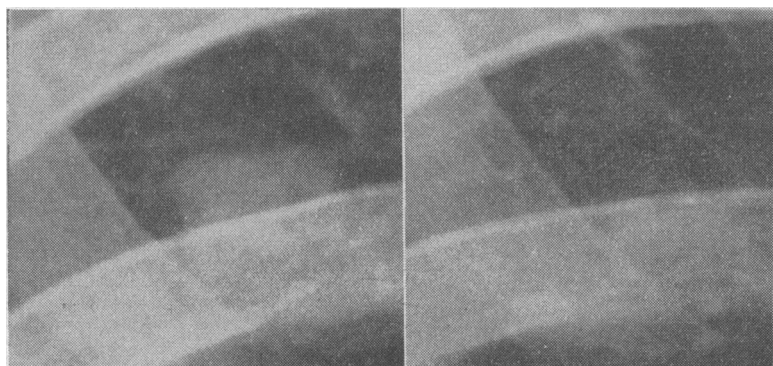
Case 3. Left: Part of chest x-ray film taken on June 17, 1959, showing pulmonary metastasis. Right: x-ray film of same part of chest taken on August 8.
